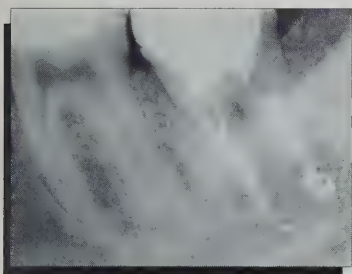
Radiographie prise lors de l'examen d'urgence où on note un dépassement important de la gutta.
